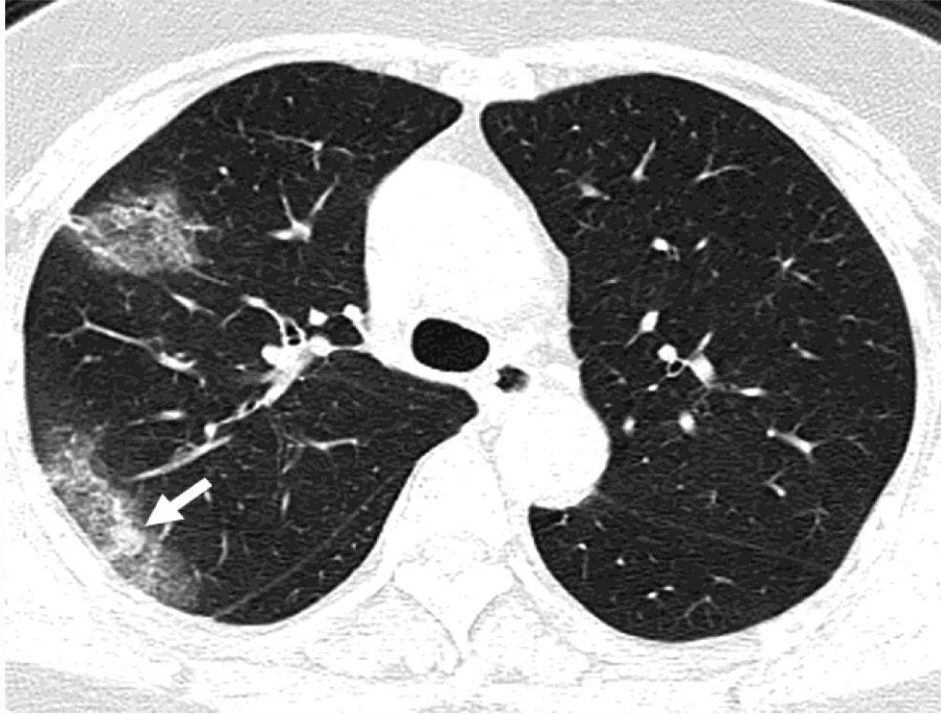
Further increase in extent of ground glass changes with new cavity in right lung (arrow, 2d) as well as new areas of consolidation (arrow, 2e) are seen on CT 5 days after presentation.
